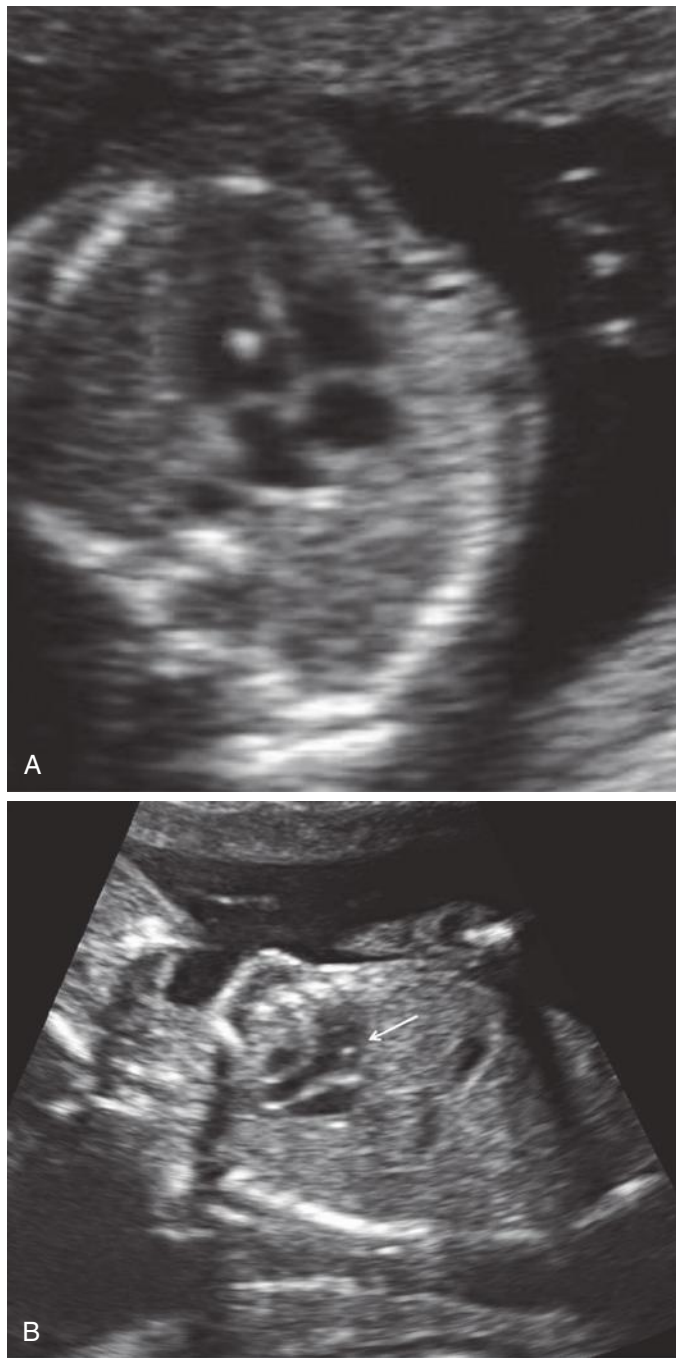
A, Apical four-chamber cardiac view demonstrating the presence of an echogenic intracardiac focus in the right ventricle. B, View of the left ventricular cardiac outflow tract demonstrating the presence of an echogenic intracardiac focus (arrow) in the left ventricle.
